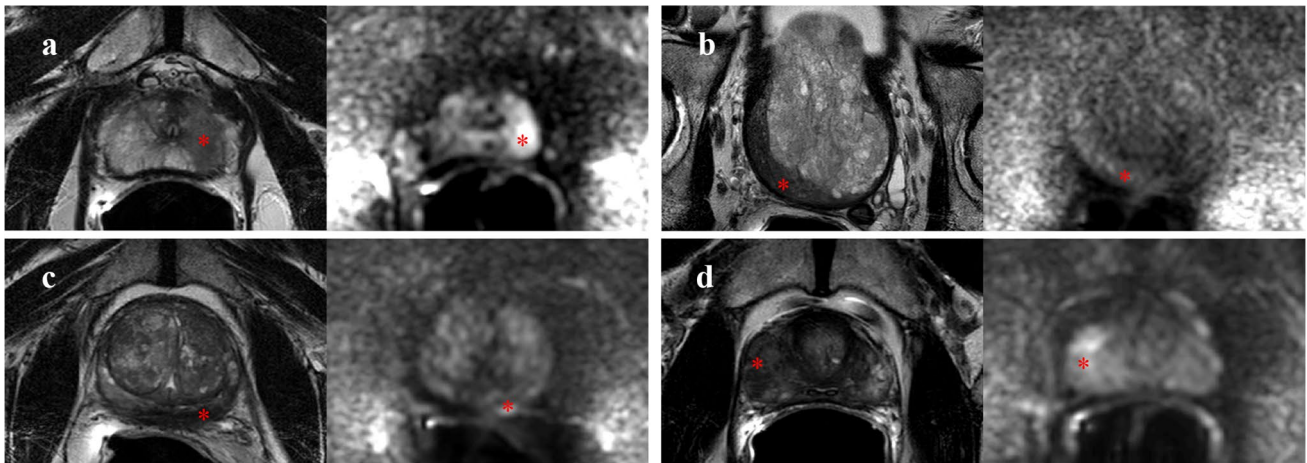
True- and false-positive mpMRI PIRADS 5 lesions; axial T2 W (right) and b2000 DWI (left): a prostate adenocarcinoma, b high-grade prostatic intraepithelial neoplasia (HGPIN), c chronic inflammation with diffuse histiocytes, and d necrotizing granulomatosis after BCG therapy
